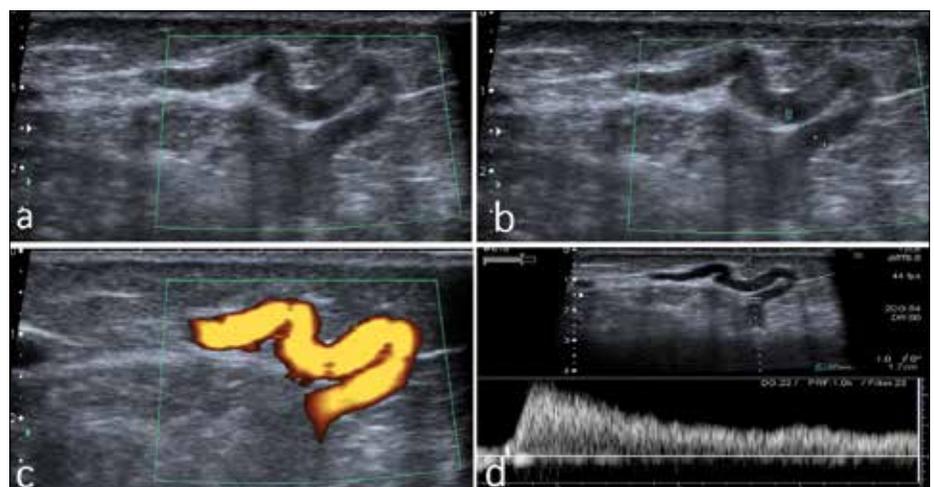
a-d. Sonographic evaluation of PV. PV obliquely perforates the deep muscular fascia and associates with the superficial vein (a), diameter of PV measured at the supra-fascial–subfascial connection level (b), augmentation of blood flow by compression of the limb below PV and Valsalva's maneuver are used to assess valvular integrity with color flow imaging (c), and spectral Doppler imaging (d)
